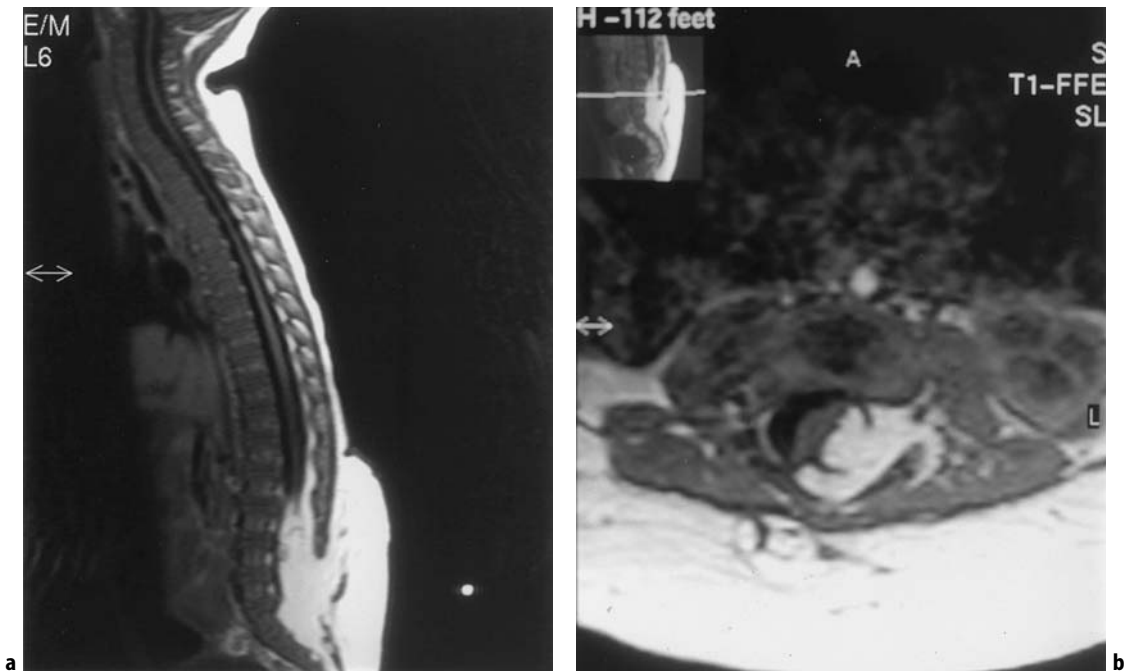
a Lumbar lipomeningocele. Sagittal T1-weighted MR scan, demonstrating a low-lying conus associated with a lipomeningocele. The spinal cord ends in a lipoma, which itself is continuous with the subcutaneous tissues and is coupled with a defect in the lumbar laminae. b Lumbar lipomeningocele. Axial T1-weighted MR image, revealing the relationship between the conus and the lipoma itself.
